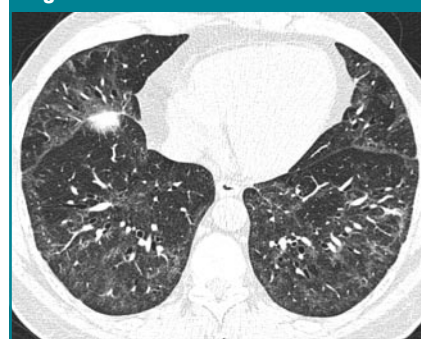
Transverse CT scan shows nonspecific interstitial pneumonia.
